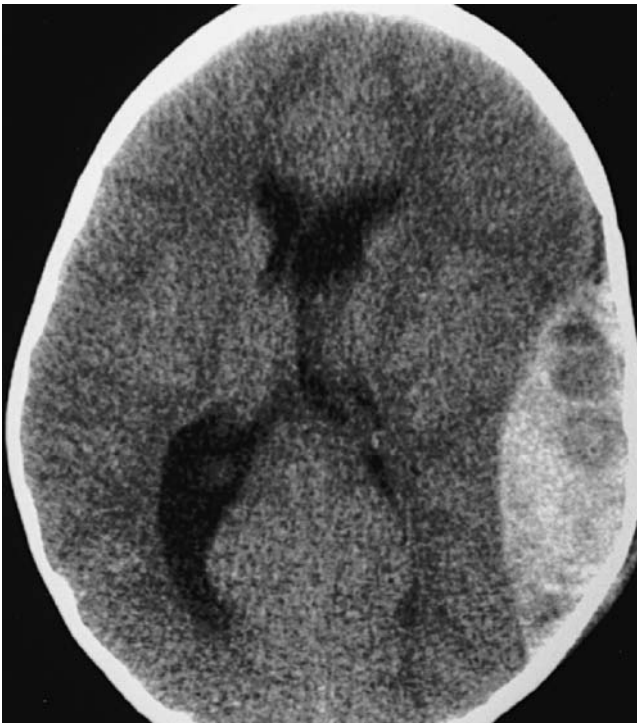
Epidural hematoma (EDH). This 11-month-old boy presented with progressive lethargy and vomiting after falling 2 ft off of a bed. Several hours after the injury, he became unresponsive with dilated, nonreactive pupils. This head computed tomographic scan shows a large EDH, with intermingled hypodense areas representing active bleeding. Note also the midline shift and the compression of the ipsilateral ventricle. After an emergency craniotomy, the patient made a full recovery.
